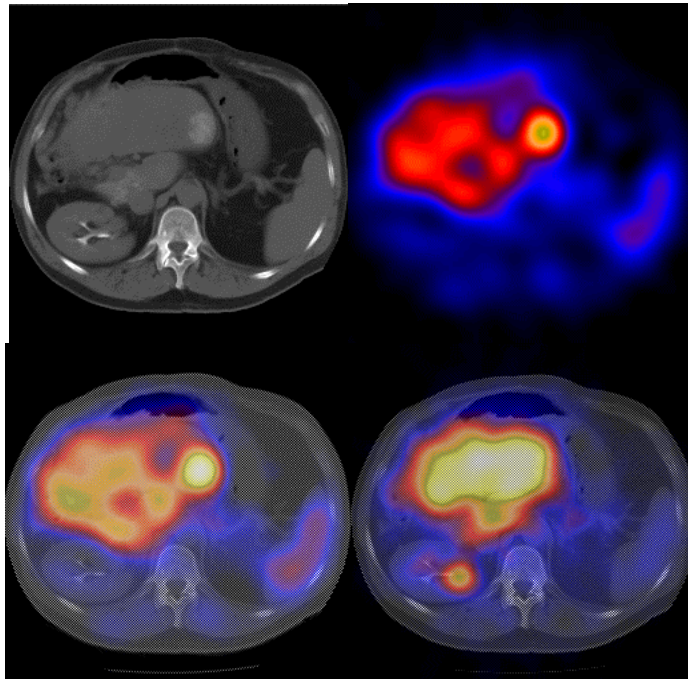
Transaxial images, following registration, of a patient with liver metastases of a carcinoid tumor. (Left panel) one metastasis is faintly visible as a brighter region in the CT image (top left) and as a hot spot in the corresponding MIBG SPET image (top right). Fusion images obtained after 16 h (bottom left) and 24h later (bottom right).
